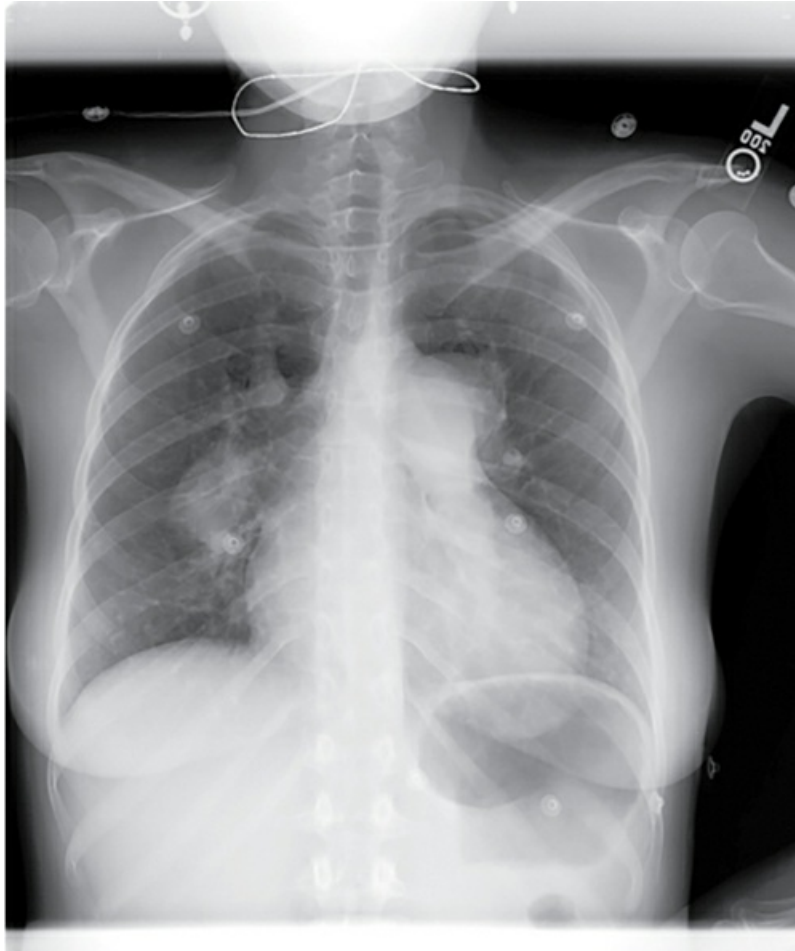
Chest radiograph of a patient with pulmonary hypertension attributable to recurrent thromboemboli. Central pulmonary arteries are large bilaterally, but rapid tapering of vessels occurs distally.
